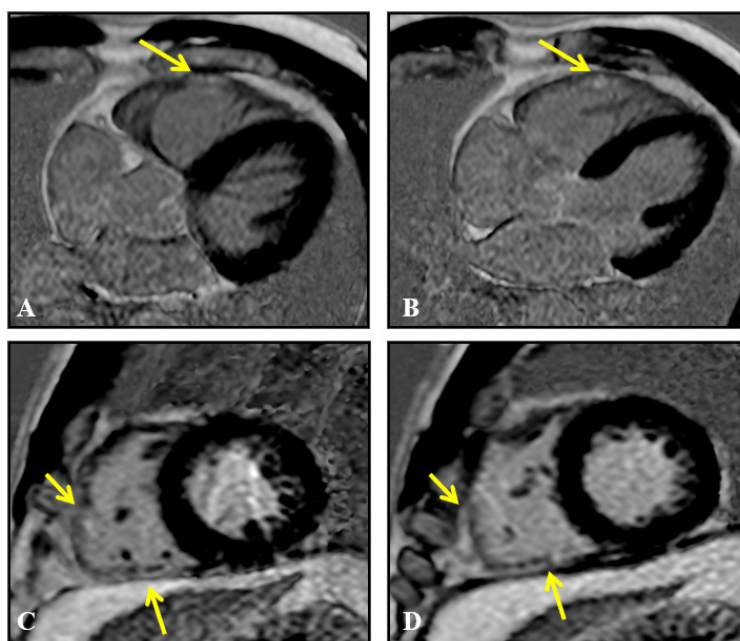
Magnetic resonance imaging, late gadolinium enhancement sequences, 4 chambers (A and B) and short axis (C and D) showing pathological late enhancement areas in the myocardium of the inferior and lateral segments of the right ventricular free wall (arrows), without associated left ventricular involvement.
